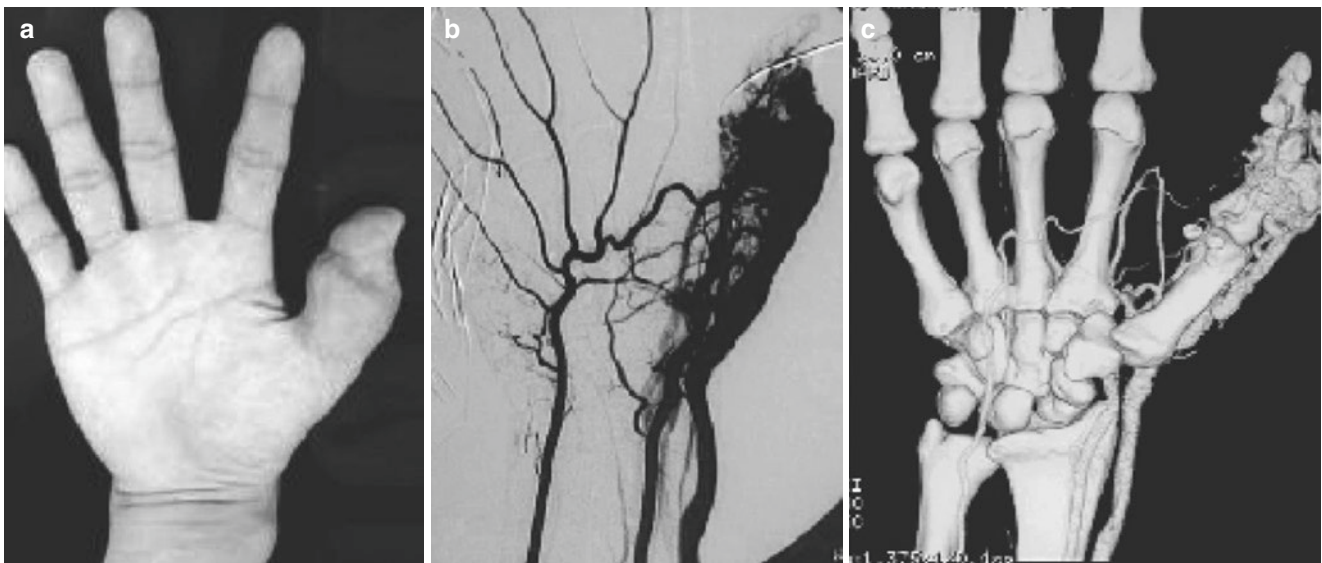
Surgical treatment of arteriovenous malformations of the right thumb. (a) Preoperative pulsatile masses in the right thumb. (b) DSA indicates the presence of a large amount of abnormal vascular imaging. (c) CTA indicates the presence of deformed vascular masses.
